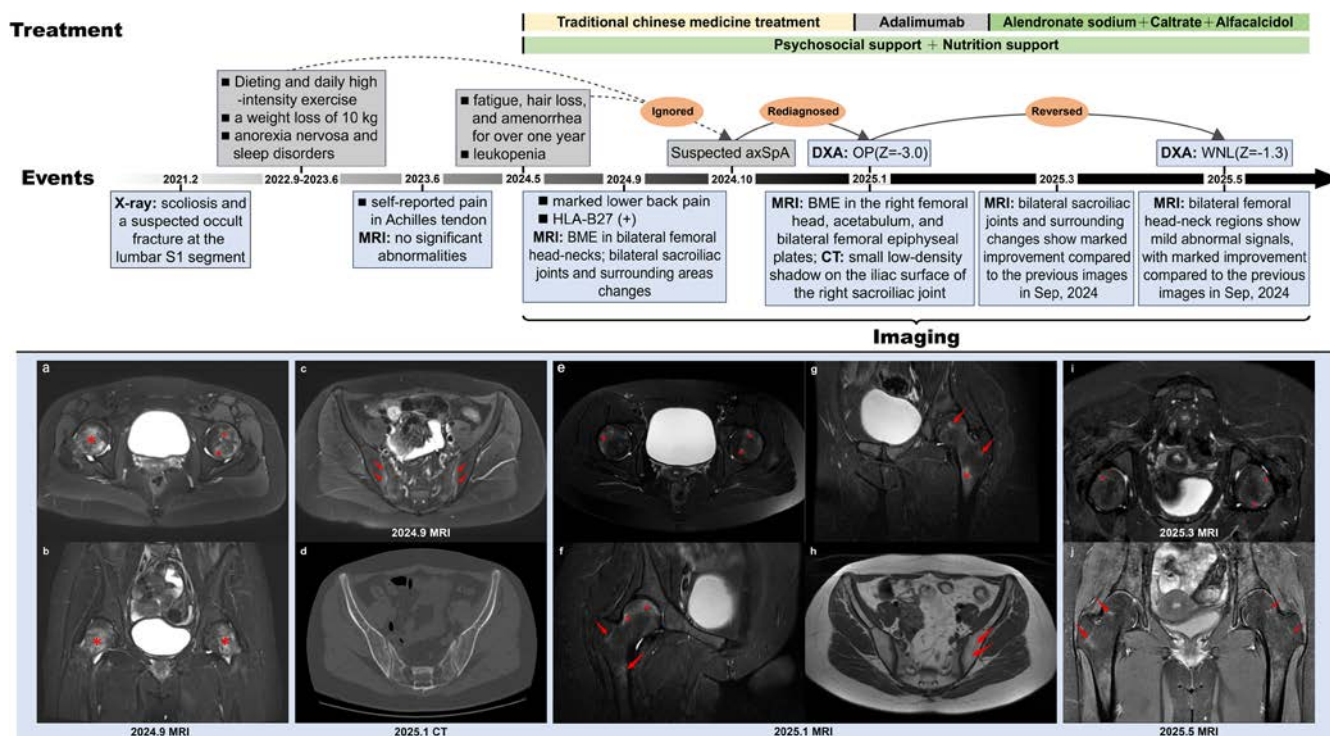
Timeline of key diagnostic and treatment information and imaging changes in this case. Images (a–c) and (e–g) showed visible BME; (d) revealed significant OP; (h) showed uniformly distributed fatty high signals associated with OP on T1-weighted imaging, distinguishing it from the localized bone destruction and fat deposition related to AS; (i, j) were follow-up MRIs showing marked improvement and near resolution of previously noted BME. As shown in Image (h), by January 2025, the BME around the sacroiliac joints had significantly improved, with only partial fat infiltration remaining. On follow-up in March 2025, the BME in the femoral heads also showed marked improvement. Subsequently, in May 2025, a targeted follow-up MRI of both hip joints was performed, and Image (j) demonstrated that the BME had almost completely resolved compared to Image (b). BME, bone marrow edema; CT, computed tomography; DEXA, dual-energy X-ray absorptiometry; HLA-B27, human leukocyte antigen B27; MRI, magnetic resonance imaging; OP, osteoporosis; WNL, within normal limits.
